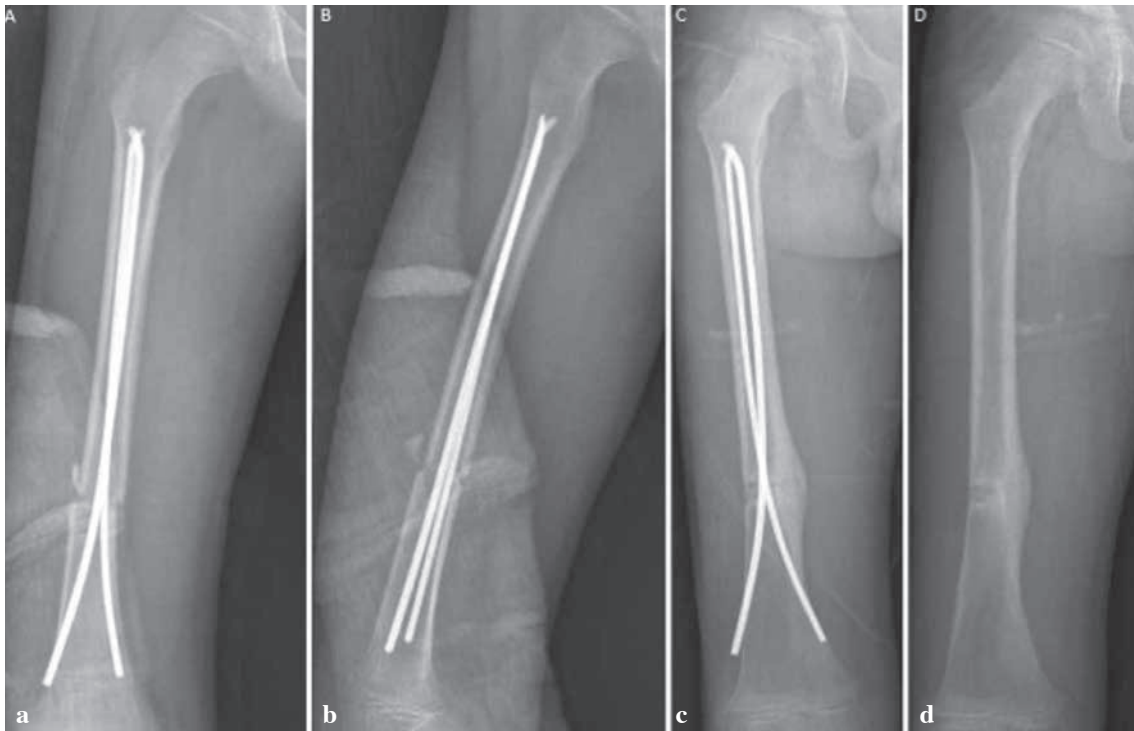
Paediatric femoral fracture treated with mini-open reduction and nailing. (a) (b) : AP and lateral post-operative radiographs ; (c) : AP view after 13 weeks ; (d) AP view after removal of the nails.
